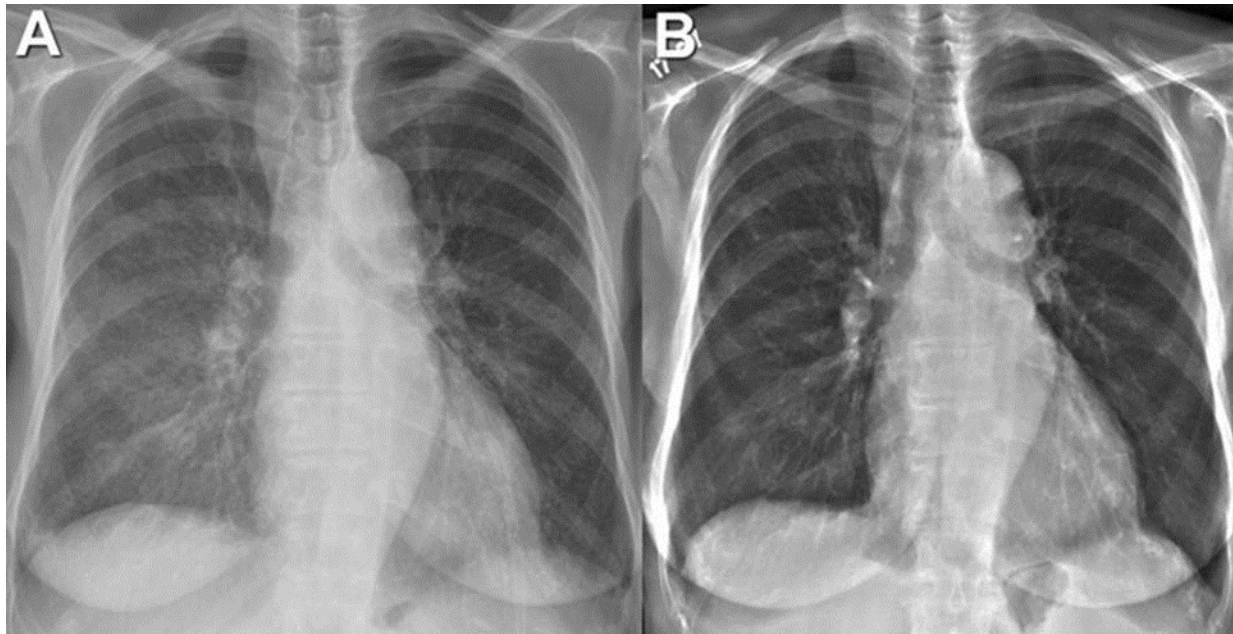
Panel A: Frontal chest radiograph obtained at presentation, when the patient complained of worsening shortness of breath. Panel B: 3 years earlier.
